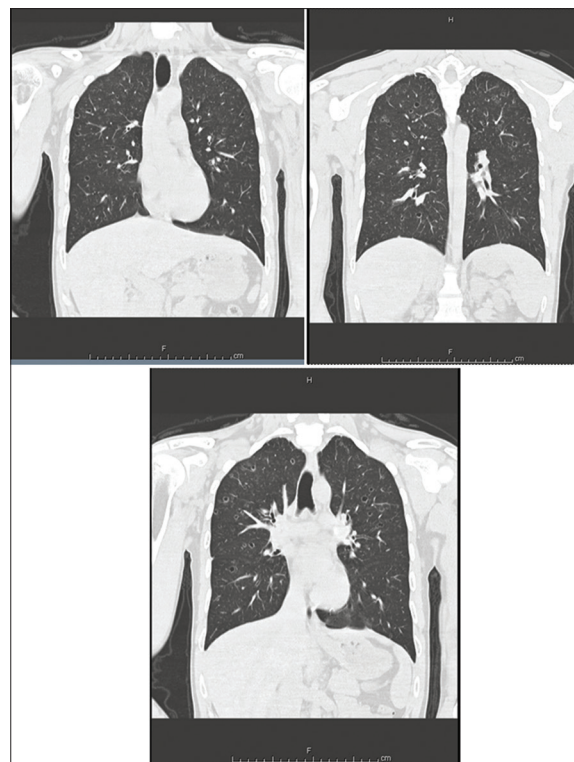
Thorax high-resolution computed tomography of case 2. The coronal cross-sections were showing typical distribution of disease with many diffuse cysts and cavities localized in upper and middle lung lobes, with some micronodules. As expected, basal regions were spared
